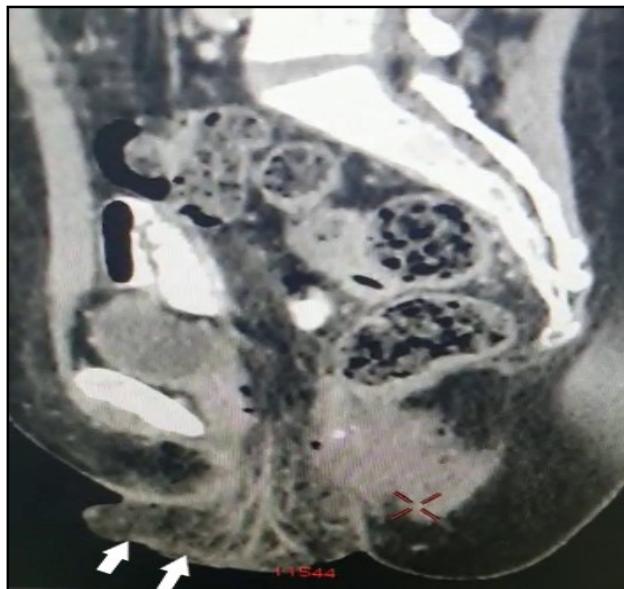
CT scan picture (sagittal section) showing prolapsed omentum through vagina.
